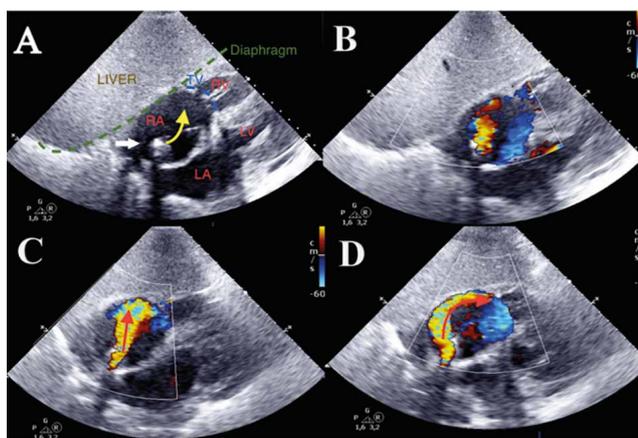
Subcostal trans thoracic echocardiography images.
